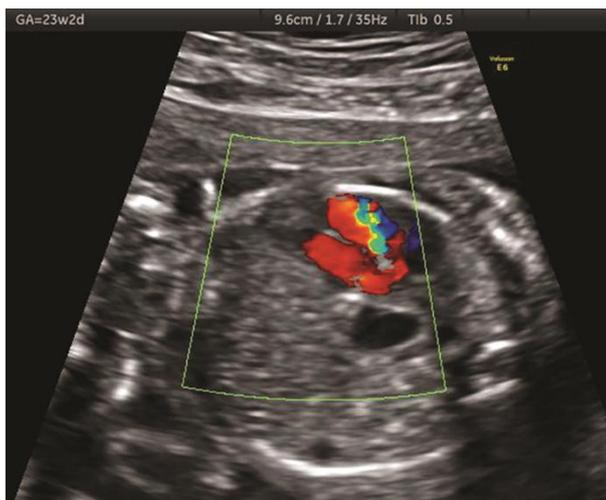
The same image as Fig 7, but with collar doppler included.
